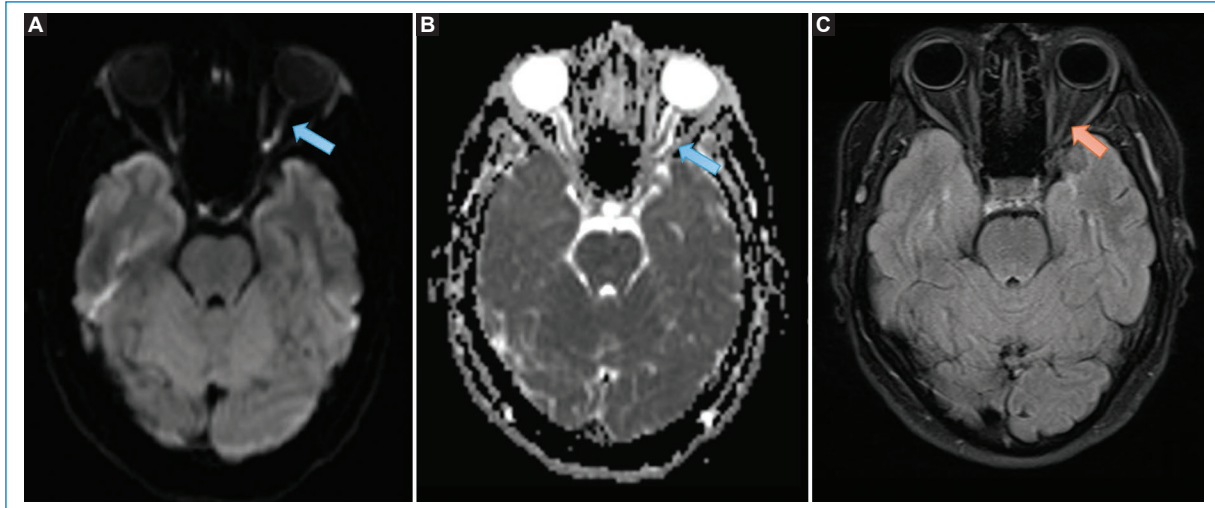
Lesion in the posterior region of the left intraorbital segment with restriction on DWI (A) diffusion sequences and ADC map (B), without representation on FLAIR (C) sequence, consistent with optic nerve ischemia following a cosmetic procedure (arrow). The left optic nerve is visible (C, arrow). No other lesions were found in the remainder of the brain parenchyma.
